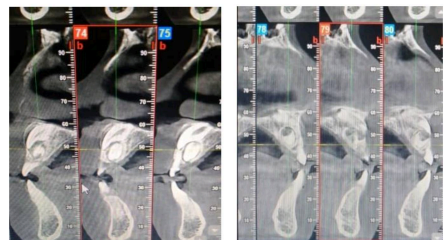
CBCT images of impacted mesiodens*
